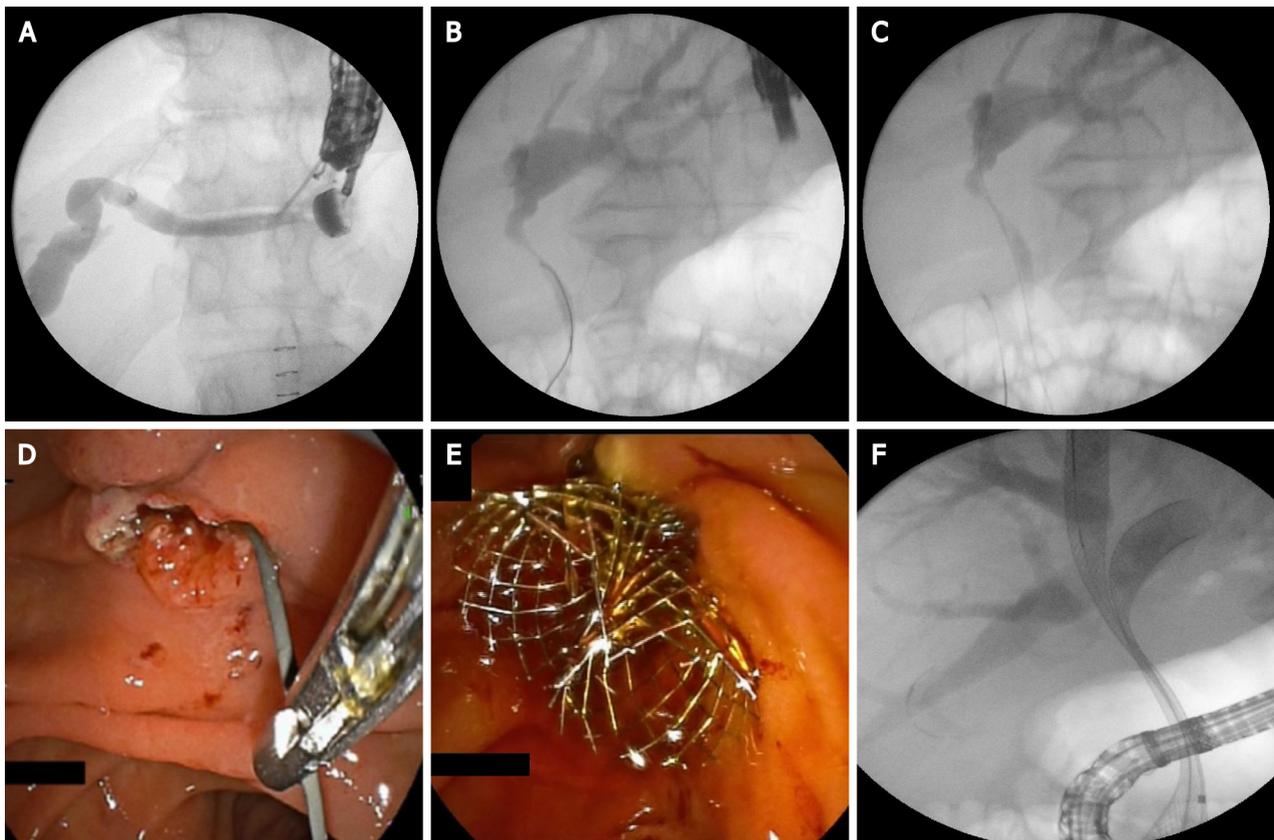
Endoscopic ultrasound-guided rendezvous technique. A: Puncture the left hepatic duct with 19G needle; B: Guide-wire insertion in bile ducts; C: Guide-wire insertion transpapillary in the duodenum; D: Grasping the guide-wire with a rath tooth forceps; E: Endoscopic image of two self-expandable metal stent (SEMS); F: Fluoroscopic image of two SEMS.
